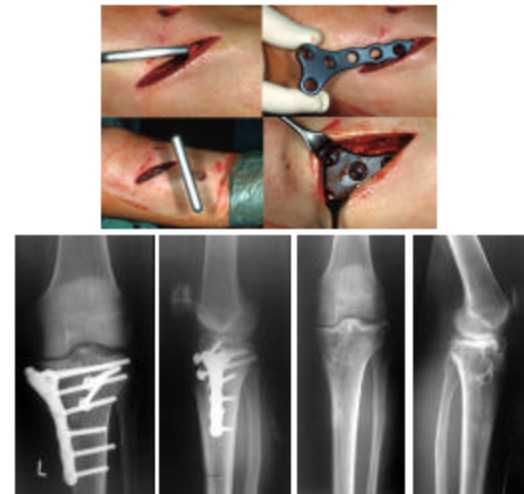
In minimally invasive fashion the fracture of figure 5 is reduced. The radiographs show a good reduction, after removal of metalworks no loss of reduction
